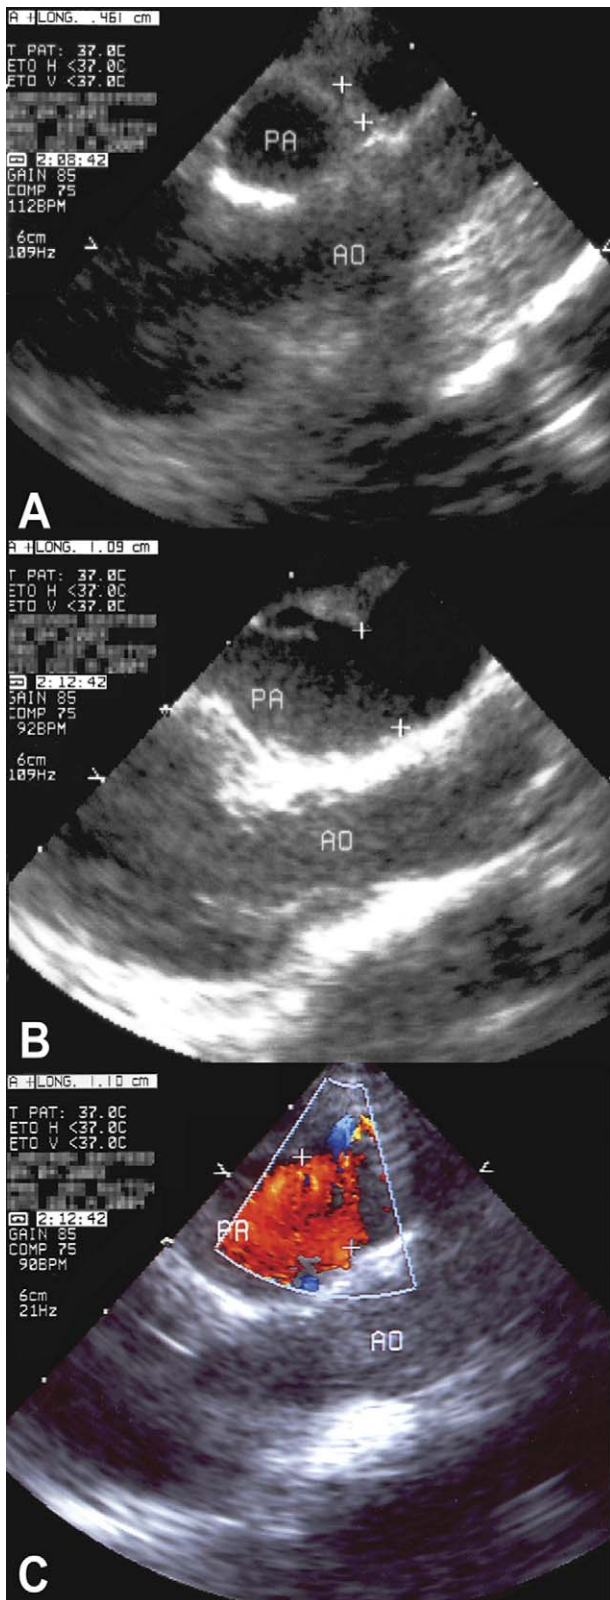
Intra-operative trans-oesophageal echocardiography, showing the narrowing of the pulmonary artery (A = 0.46 cm) with FloWatch[®]-PAB in situ, the spontaneous reopening of the pulmonary artery (B = 1.09 cm) immediately after unclipping the FloWatch[®]-PAB, and with the colour Doppler (C = 1.10 cm) showing absence of pressure gradient. Ao: aorta; and PA: pulmonary artery.
